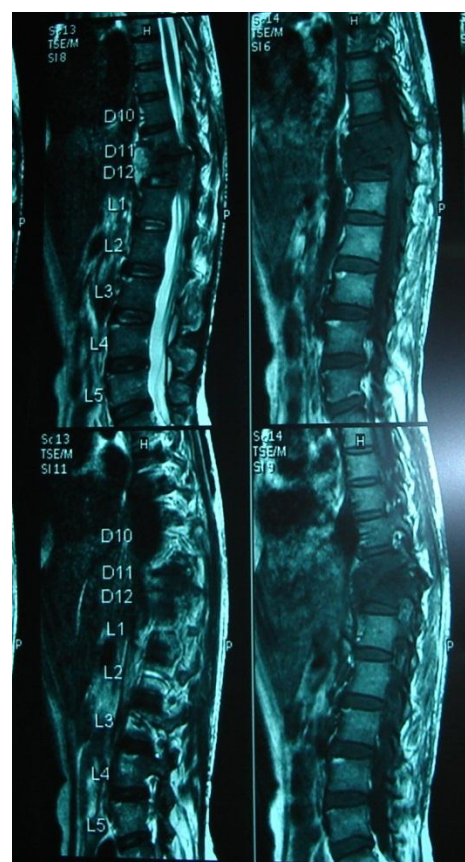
Spinal imaging (MRI) showing vertebral destruction at D11-12.
